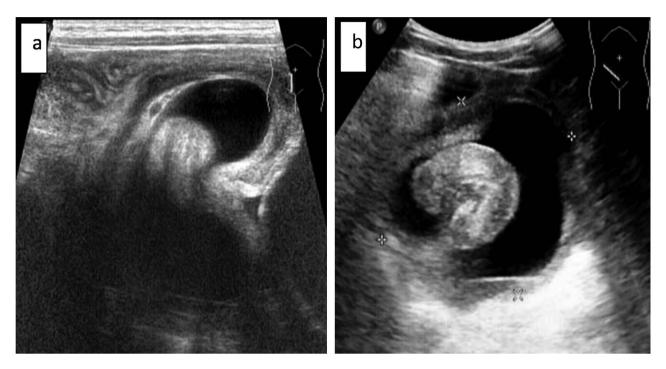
Abdominal ultrasonic images of intestinal intussusception. Longitudinal (a) and transverse (b) planes views showed a "huge cyst;" inside was the peristaltic hyperechoic bowel. No abdominal mass was found.
